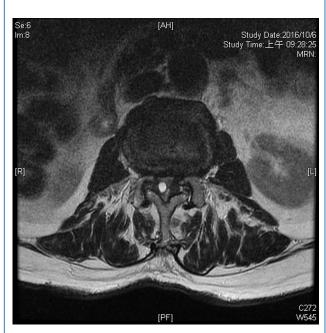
T2-weighted image shows an ovoid lesion with hyperintense center plus hypointense rim. It was approximately 6.6 mm \times 5.5 mm \times 7.0 mm in size.
